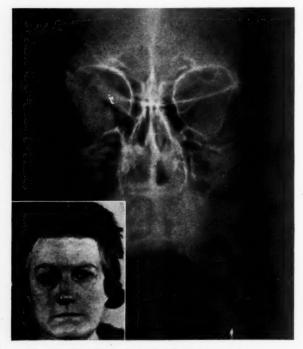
(Pfeiffer). Case 5. Meningioma of outer portion of sphenoid crest (inset). Roentgenogram showing extensive hyperostosis of the sphenoid ridge and outer wall of the orbit involving the temporal fossa. Note the prominence of the right temple of the patient as compared with the left.
